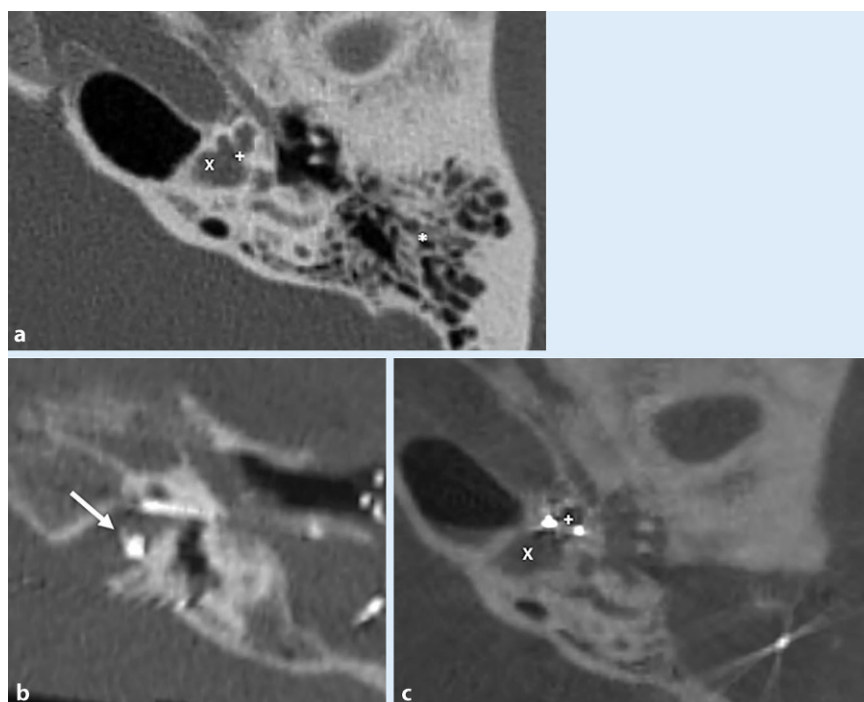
▲ Pre- and postoperative computed tomography (CT) and digital volume tomography (DVT) scans in incomplete partition type III patients. a Preoperative CT scan showing the cochlear basal turn (+) and the missing bony separation between cochlear basal turn and dilated internal auditory canal (IAC) (X). Asterisk = Mastoid. b Postoperative DVT scan with the electrode array dislocated in the IAC (arrow). c Postoperative DVT scan with the electrode array within the cochlear basal turn (+), missing lamina cribrosa and the IAC (X)
